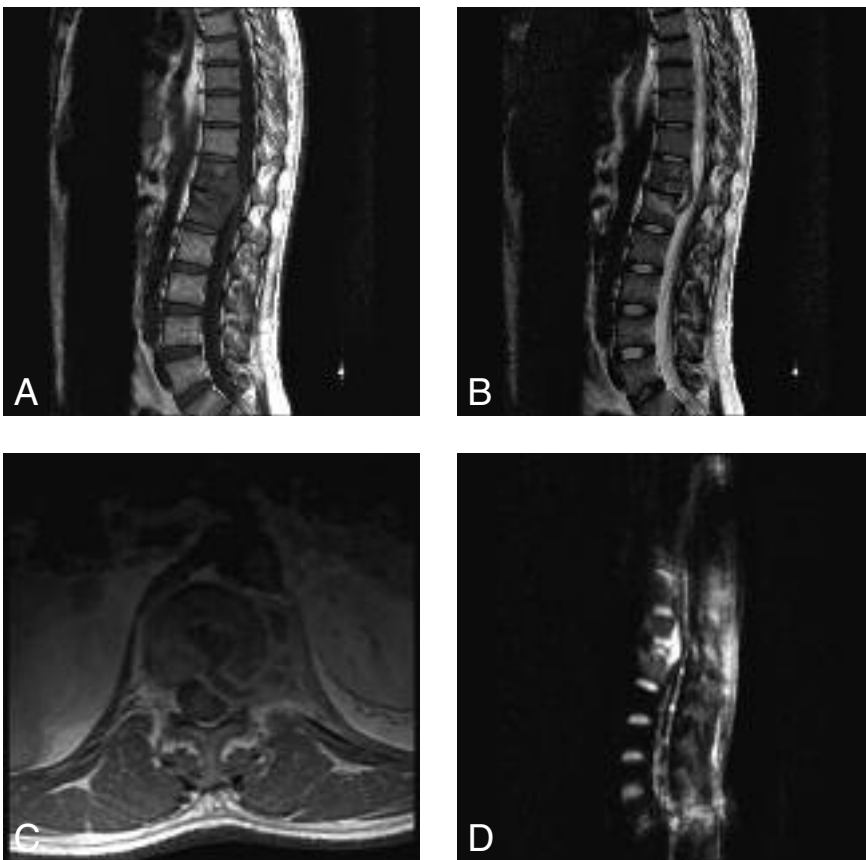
A: Sagittal T1-weighted MRI (TR/TE 600/17) shows low signal intensity metastatic lesion on both T12 and L1 vertebrae. B: Sagittal T2-weighted MRI (TR/TE 3446/130) shows high signal intensity metastatic lesion involving superior part and extension into the posterior part of T12 and L1 vertebrae. C: Contrast-enhanced axial T1-weighted MRI shows contrast enhancement in the metastatic lesion, invasion of left paraspinal and psoas muscles, involvement of the dural sac and left neural foramen. D: Sagittal diffusion-weighted MRI obtained with a b value of 300 sec/mm² shows high signal intensity metastatic lesion.
